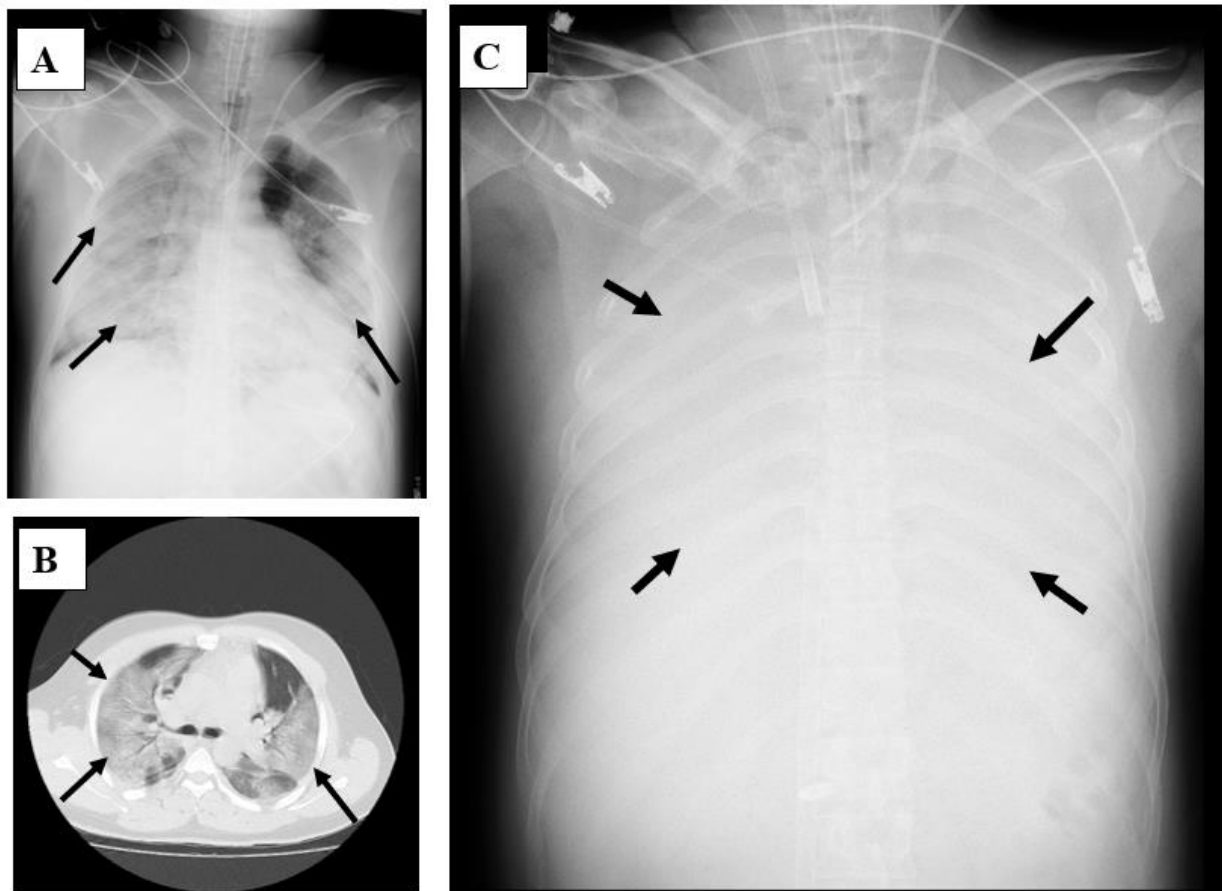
Chest X-ray (A and C) and computed tomography (B) findings of a 26-year-old male COVID-19 patient. Bilateral massive ground-glass shadows are seen on admission (A and B, arrows), but two days later, the shadows are worse, and both lung fields and the heart cannot be seen (C, arrows); the patient survived following remdesivir treatment and extracorporeal membrane oxygenation (ECMO).
